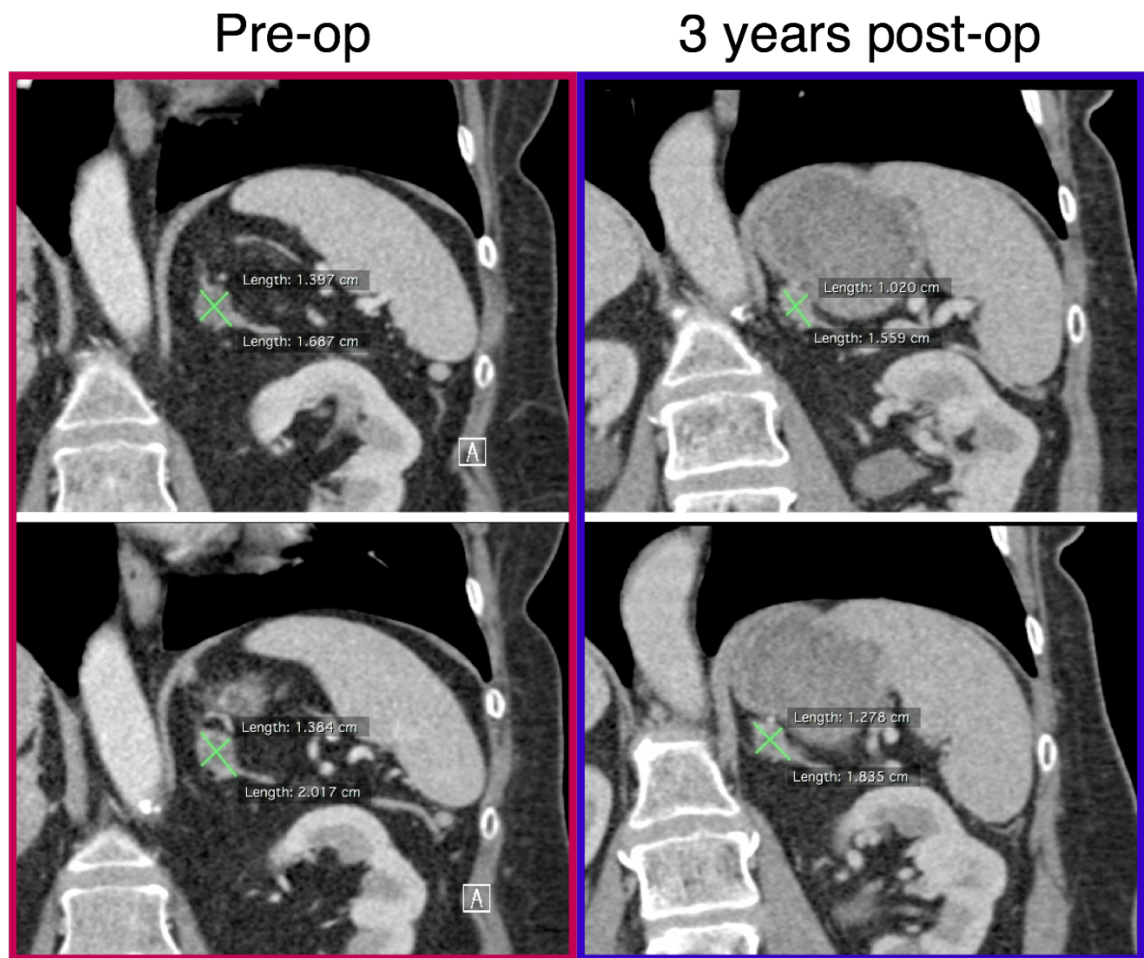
Pre and post-op portal venous phase CT images of the abdomen
